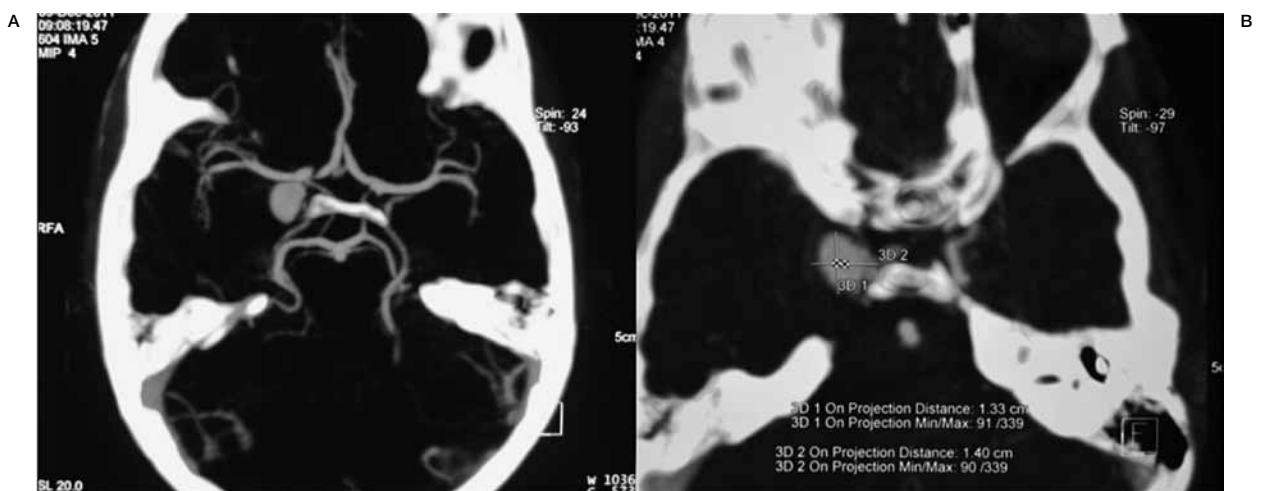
CT angiography of the brain (MIP images) after 2 weeks reveal a right intracavernous internal carotid artery aneurysm measuring 13.2×14.1×10.2 mm.
